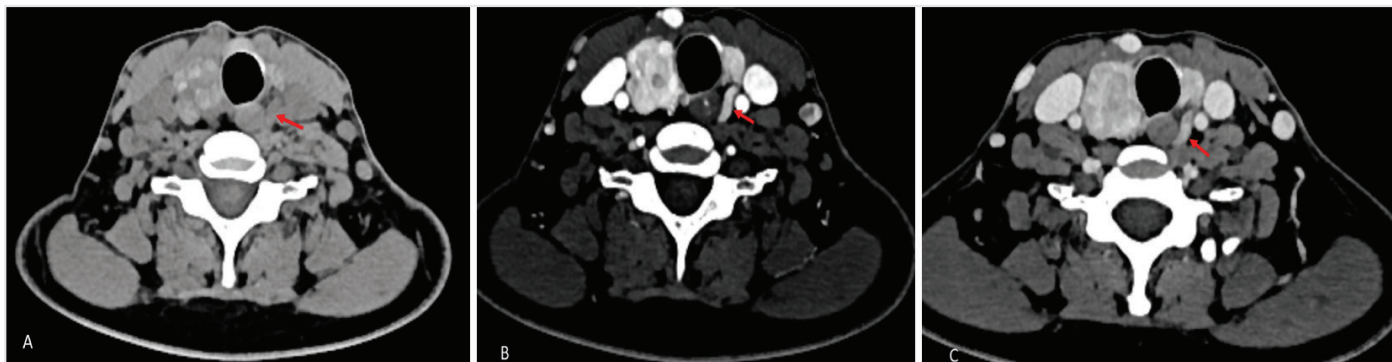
In a 48-year-old female patient followed up for recurrent multinodular goiter after total thyroidectomy, a 4D CT image shows a lesion located along the inferior part of the left lobe, between the ICA and the esophagus. The lesion is A) hypodense relative to thyroid parenchyma on pre-contrast sections, B) homogeneously enhances in the arterial phase, and C) shows washout in the venous phase, consistent with a parotid adenoma (red arrow)
